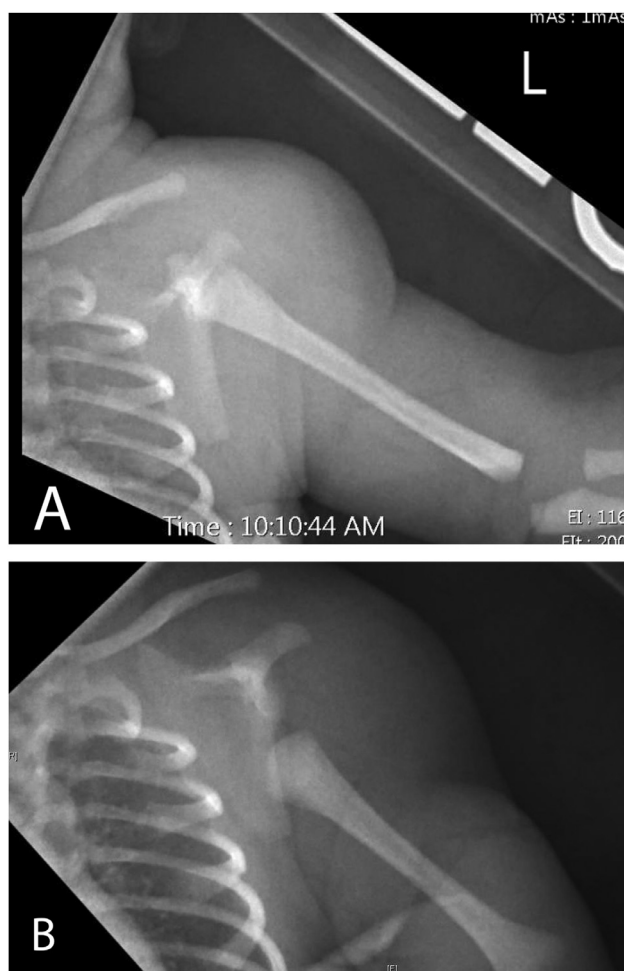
Anteroposterior (A) and lateral (B) radiograph showing a dislocated shoulder in the newborn several hours after delivery.
